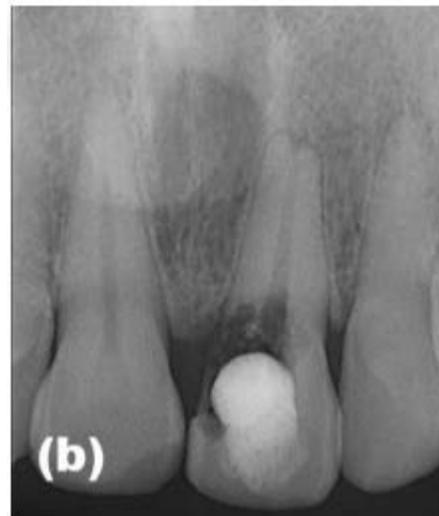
intraoral periapical radiography revealed a poorly defined radiolucent lesion
